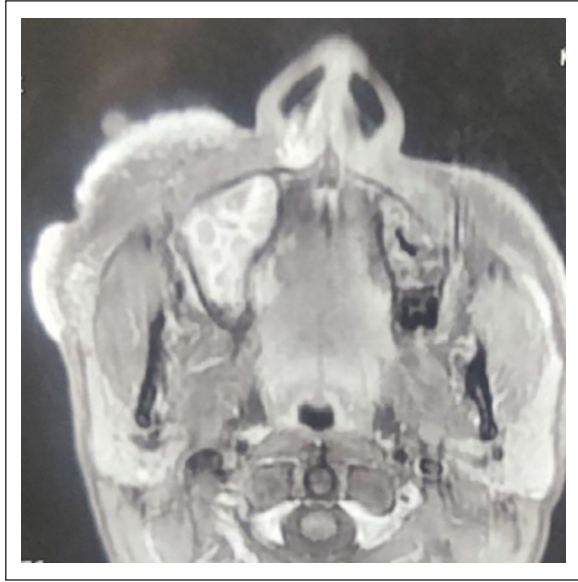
Axial T2-weighted magnetic resonance imaging image shows high signal intensity lobulated soft tissue lesion involving the cutaneous and subcutaneous plane of the right side of the face.
